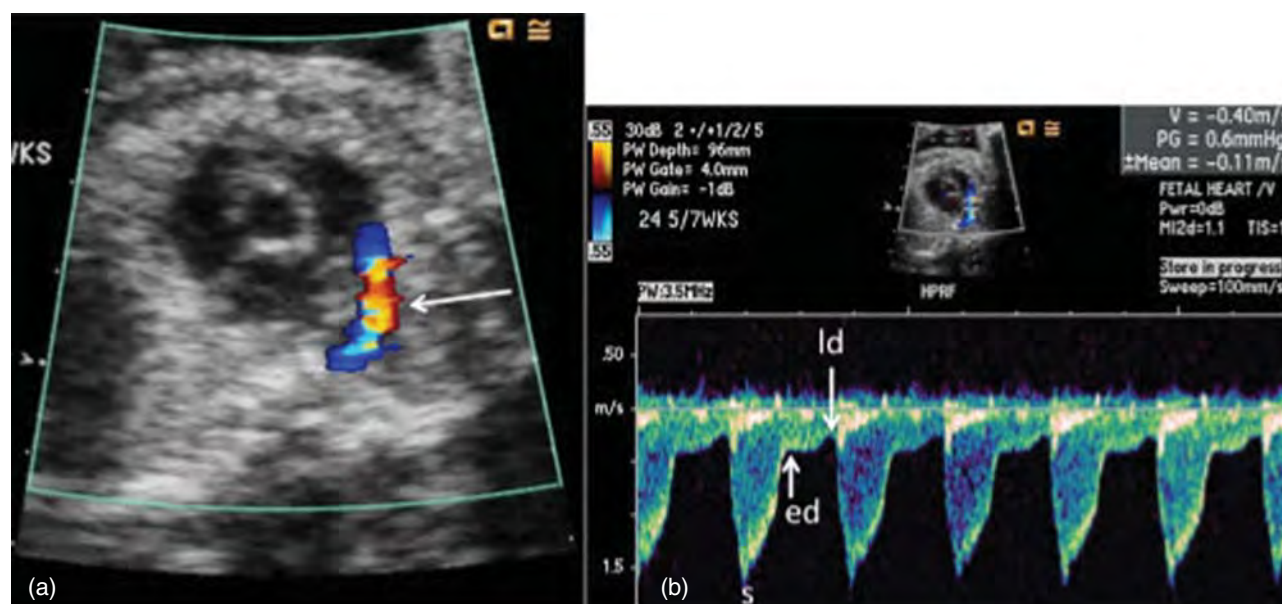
Constriction of the fetal ductus arteriosus resulting from maternal indomethacin exposure. (a) Short-axis image near the base of the fetal heart showing color Doppler aliasing (arrow) in the ductus with (b) corresponding spectral Doppler signal demonstrating increased velocities in systole (s), early diastole (ed), and late diastole (ld).
